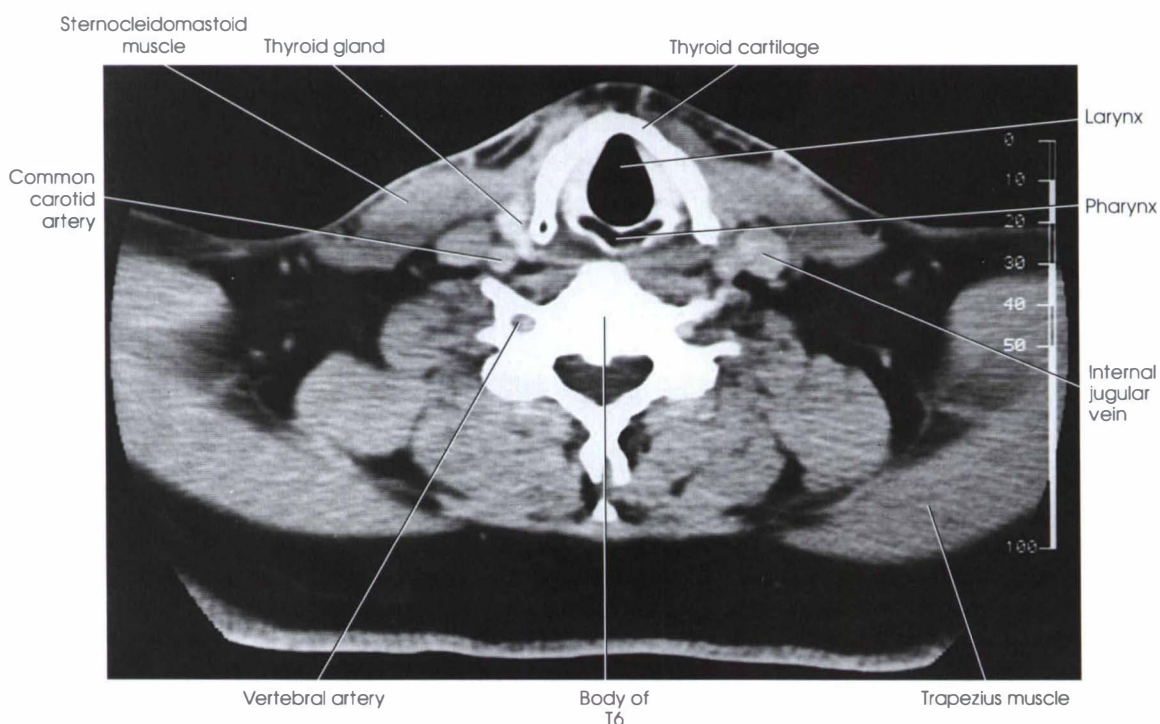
CT image through the C6 corresponding to Fig. 27-11.
